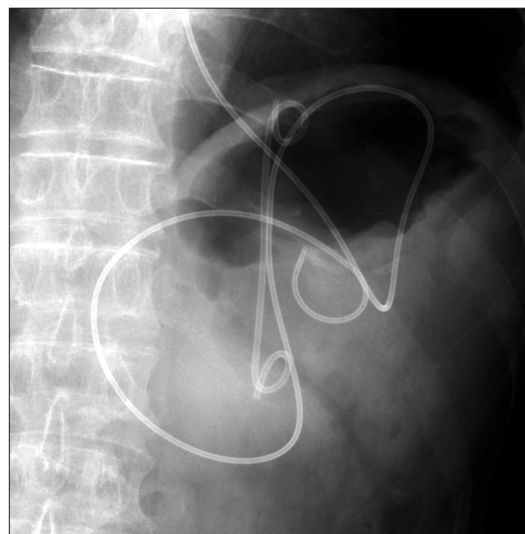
Radiograph showing a double pigtail plastic stent and a nasocystic catheter in the pancreatic pseudocyst.
